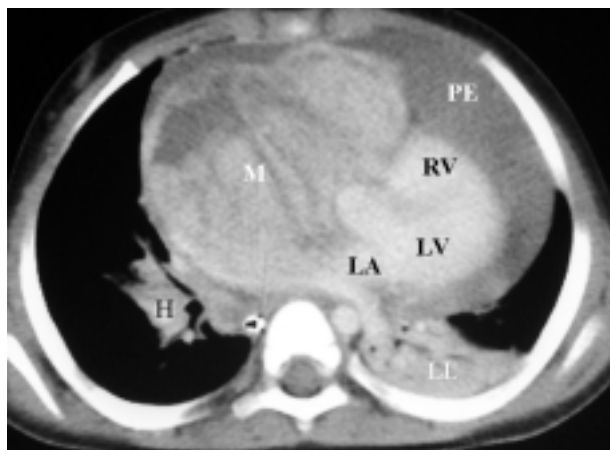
Single axial image from spiral computed tomography of the chest shows a large, heterogeneous enhancing mass (M) located anterior and to the right of the cardiac structures. It extends towards the right hilum (H) with atelectasis of the left lower lobe of the lung (LL). LA = left atrium, RV = right ventricle.
